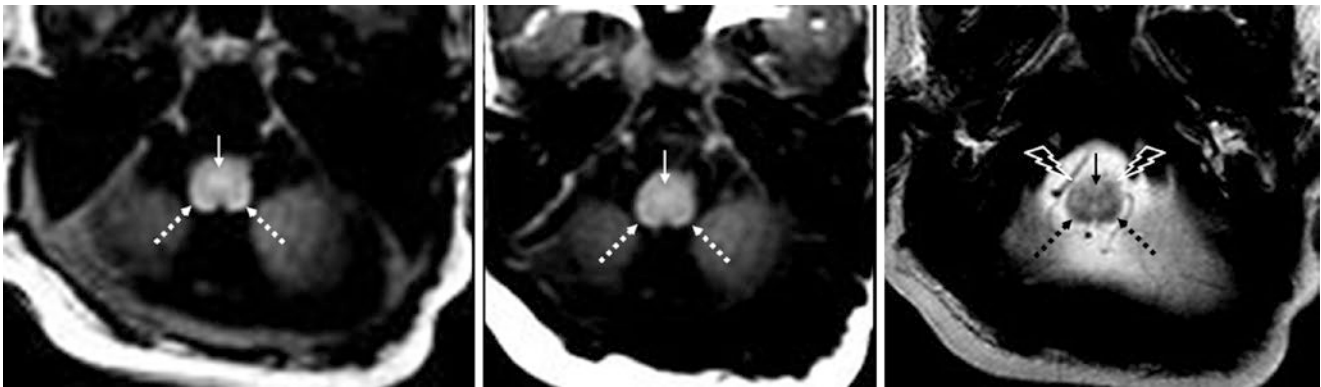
A 3-day-old term neonate had a normal 3T MRI, including spoiled GE T1WI (*left*), SE T1WI (*middle*) and SE T2WI (*right*). Note the mildly T1-bright and T2-dark pyramidal decussation (PD) (*tiny*
